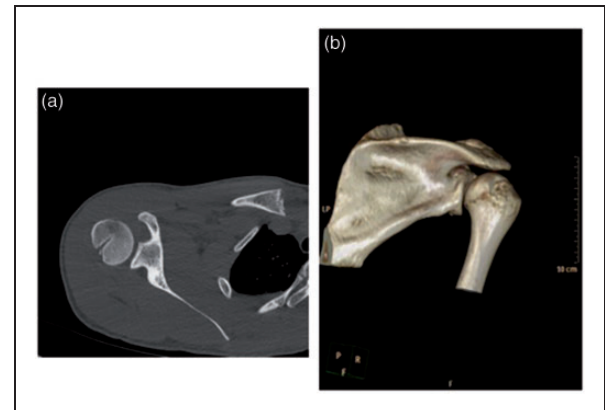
(a) Axial computed tomography image of the shoulder and (b) three-dimensional reformat show the previous Hill-Sachs remplissage without any sign of re-injury in the same shoulder.
